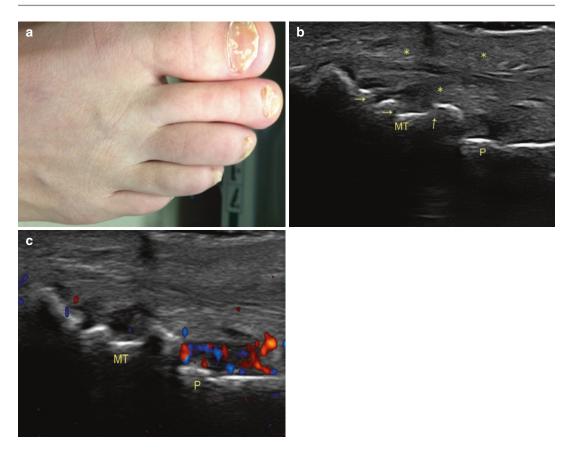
(a) Dactylitis of the right third toe in a 31-yearold man with (b) soft tissue swelling, synovitis (*asterisks*) erosions (*arrows*) and (c) synovitis with power Doppler
